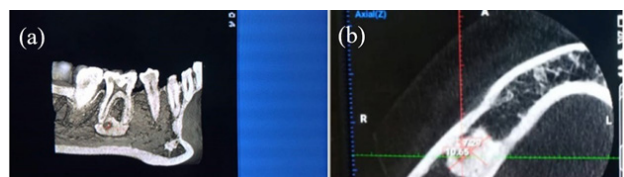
Case 1: CBCT sections of radiopacities adjacent to LR3 and LR6 prior to orthodontic treatment showing sagittal plane (a) and axial plane (b) views. The CBCT clearly shows the radiolucent area in the middle of the DBI
